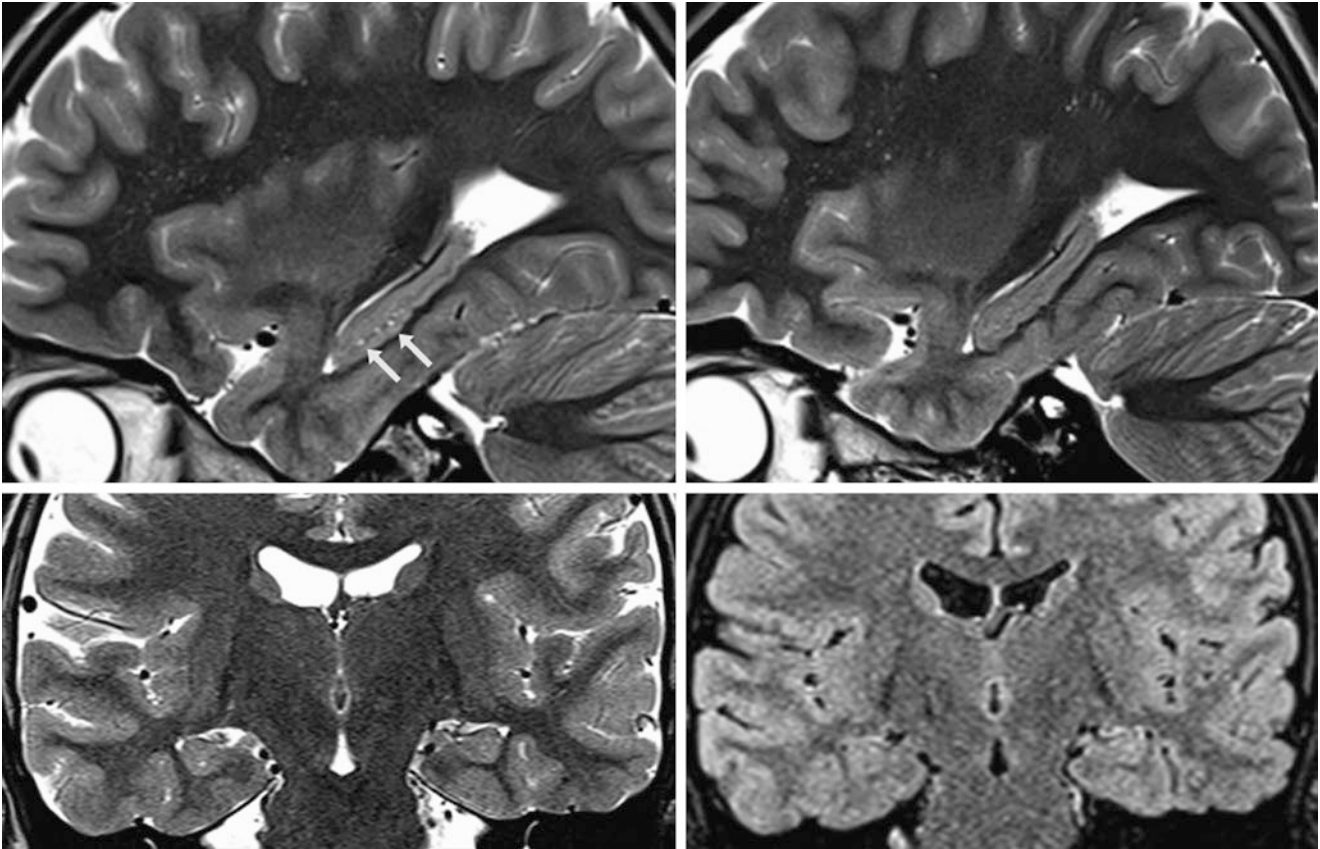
A 10 year old had a 3 T MRI that depicted very tiny cysts within the right hippocampal sulcus (*arrows*) on sagittal T2WI of the right side (*top left*), not seen on the left side (*top right*). These may
